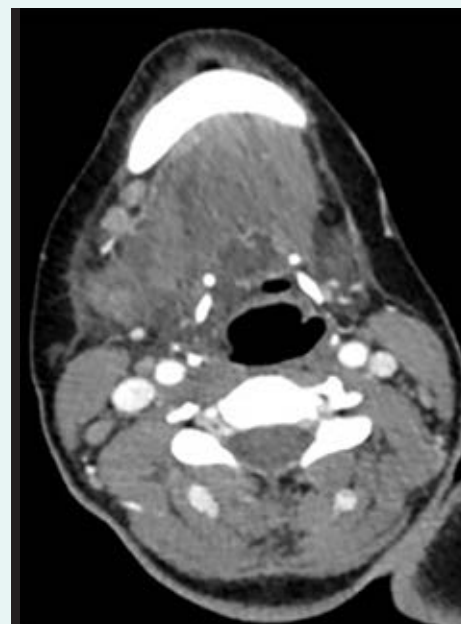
Computed tomography of the head and neck
